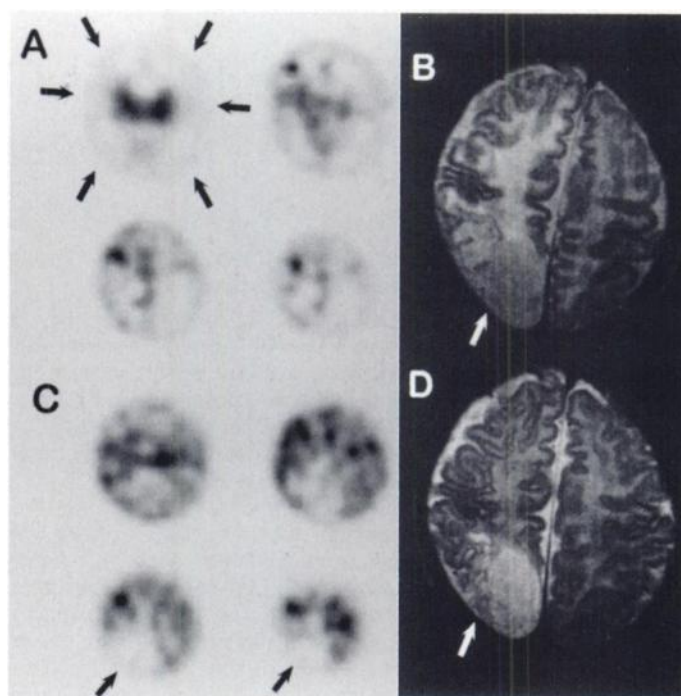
Patient 3. (A) Initial ^{99m}Tc -HMPAO SPECT image reveals marked hypoperfusion in bilateral frontal, parietal and occipital areas (arrows). (B) T2-weighted axial MR image shows localized high-signal-intensity lesion in right parieto-occipital lobe with loss of normal gray matter (arrow). (C) Follow-up ^{99m}Tc -HMPAO SPECT image demonstrates decreased perfusion in bilateral parieto-occipital regions, especially on right side (arrows). (D) T2-weighted axial MR image reveals persistence of right parieto-occipital lesion (arrow) accompanied by return of normal gray matter in immediately adjacent areas.
